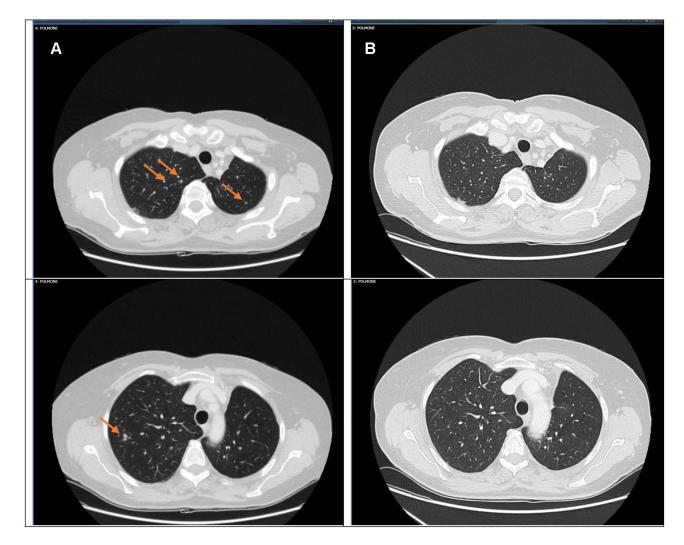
Chest CT scan. (A) Baseline disease in multiple small lung nodes. (B) Complete disease response after 12 weeks of therapy with osimertinib.
